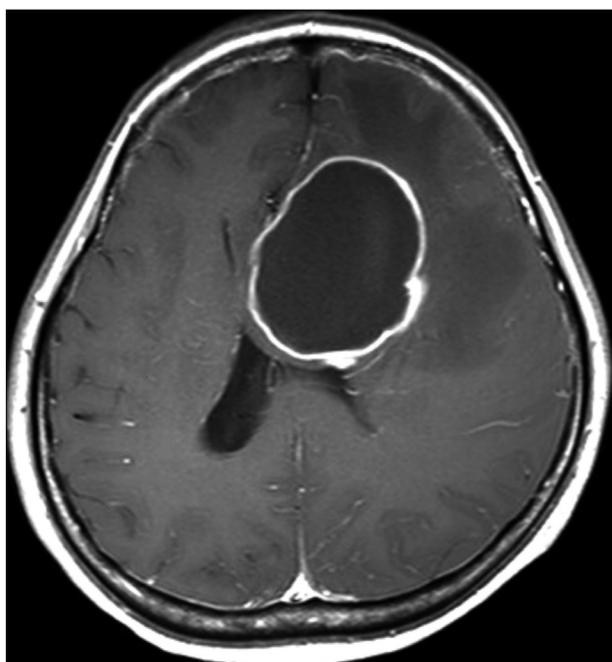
Axial T1-weighted gadolinium-enhanced MRI demonstrating large rim-enhanced cystic tumor in the left frontal lobe.
